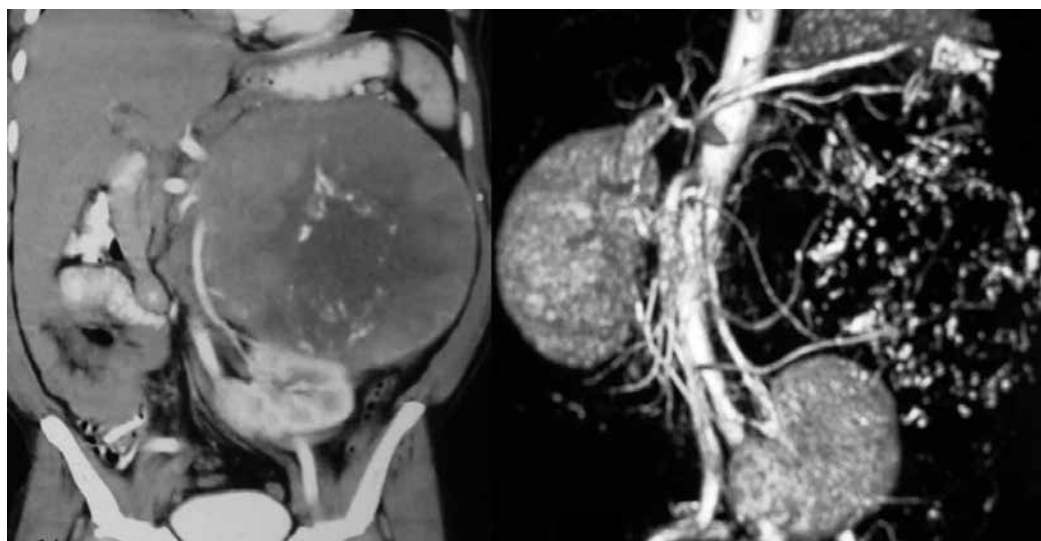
CT in preoperative planning in case of giant adrenal oncocytoma. Coronal section of contrast enhanced CT demonstrating a giant left adrenal oncocytoma with left kidney lying in transverse plane at iliac crest. The left renal vessels are stretched over the inferolateral aspect of the adrenal mass. CT-angiography shows multiple feeding vessels to the tumor.
